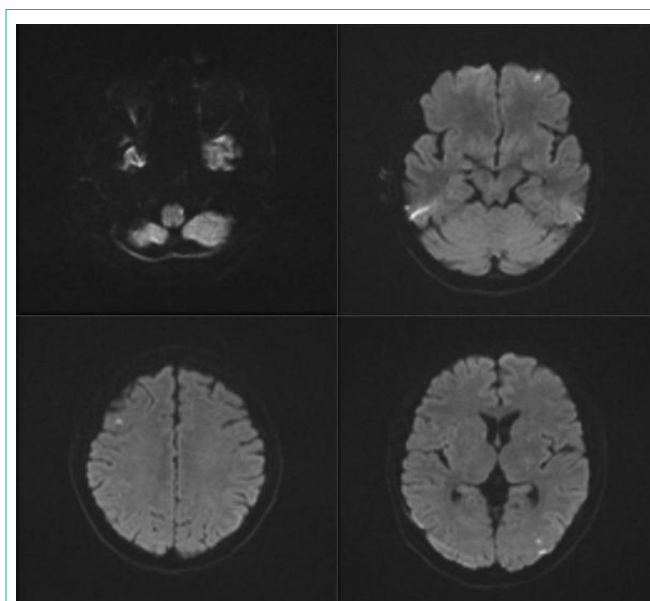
Multiple ischemic lesions in MRI Diffusion-weighted Imaging (DWI) (left dorso-lateral medulla oblongata; left and right middle cerebral and left posterior cerebral artery territories).
